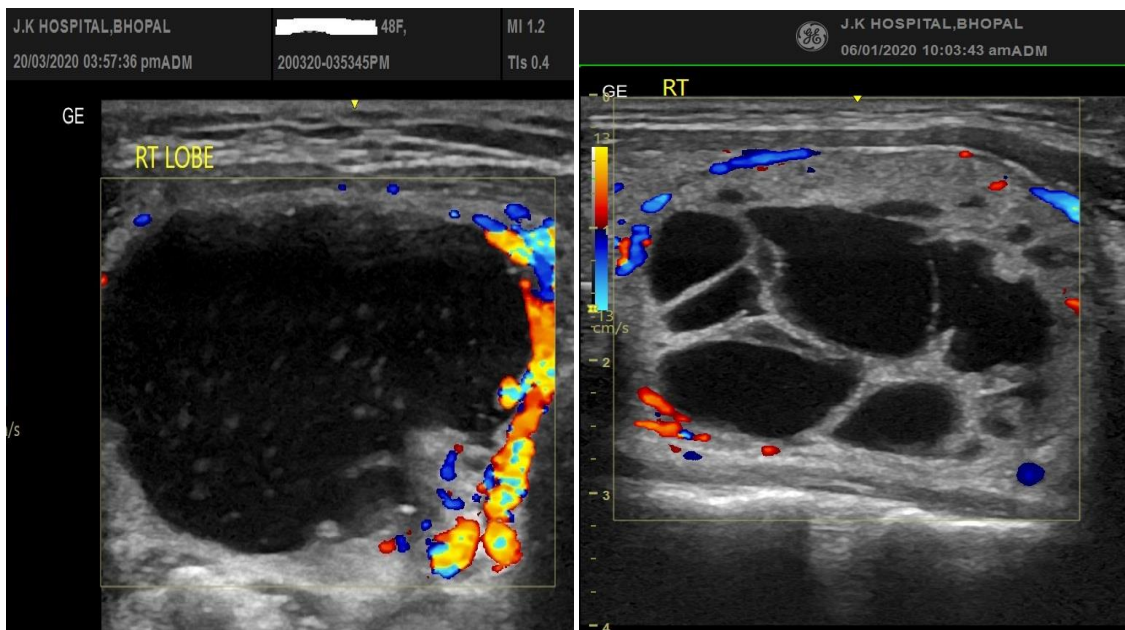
Colloid cyst/nodule (a)Doppler USG showing well defined cystic lesion with peripheral vascularity and internal echogenic content showing comet tail artefacts. (b)Doppler USG well defined wider than tall cystic lesion shows honey comb pattern with peripheral vascularity.
